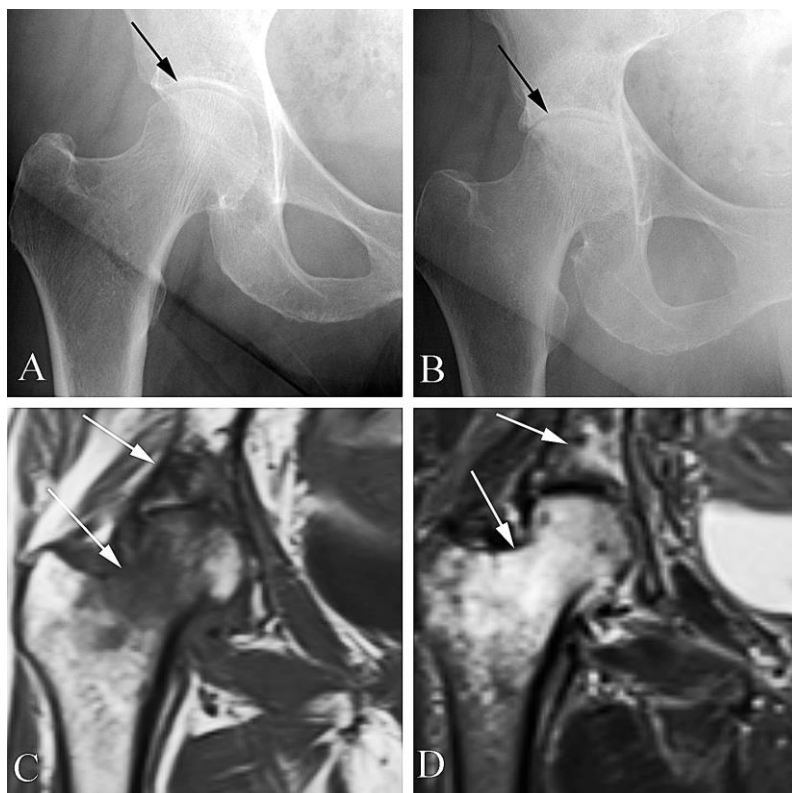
Rapidly destructive osteoarthritis of the right hip in an 80 year old woman with progressive hip pain. A. AP plain film at the onset of hip pain shows mild joint narrowing (arrow). B. AP plain film obtained six months later (with steadily increasing pain) shows marked progression of joint space narrowing (arrow). C. Coronal T1 weighted image shows extensive abnormal decreased signal intensity through the femoral neck and acetabulum (arrows). D. Coronal T2 weighted image shows abnormal increased signal intensity through the femoral head, neck, and acetabulum (arrows).
